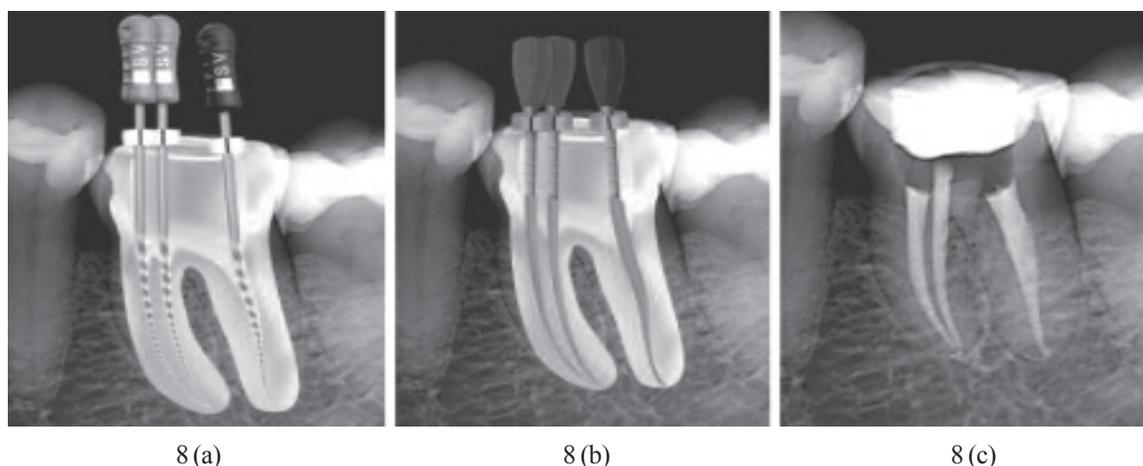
(a). GuttaCore NiTi varifiers are used to verify the final canal shape. 8 (b). GuttaCore/guttapercha obturators used for root canal obturation. 8 (c). Final radiography result after root canal obturation.
